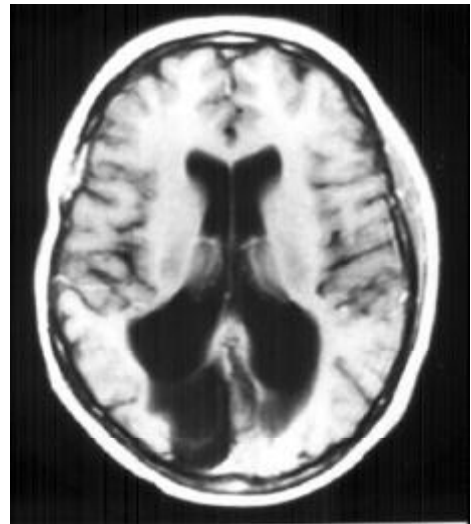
MRI from a patient 6 months after a head injury with late relief of a right tentorial hernia with compression of the right posterior cerebral artery; a right medial occipital infarct has developed.
